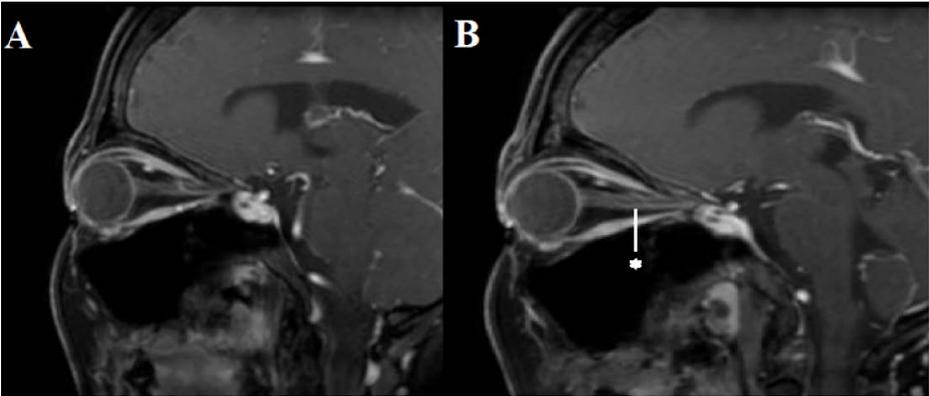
Right eye (A) and left eye (B) sagittal views of orbit MRI with post-contrast fast spoiled gradient echo sequences. The left optic nerve (B) demonstrates increased perineural enhancement (asterisk) compared to the right optic nerve (A). No mass seen within both intraconal structures.
